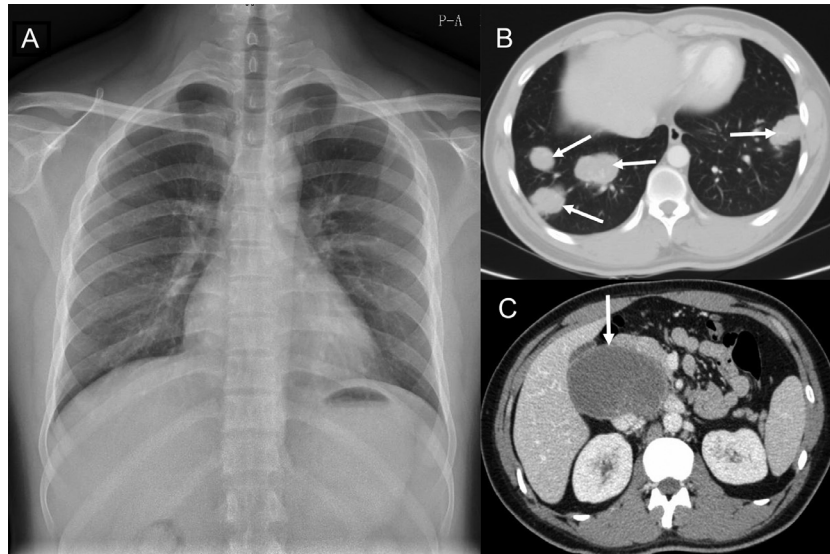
The chest X-ray image of the patient showed no obvious signs of abnormality before the operation (A) and 6 months after the operation, the contrast enhanced CT scan revealed multiple metastases in the lungs, pancreas, and retroperitoneum. (B and C, the arrows).
